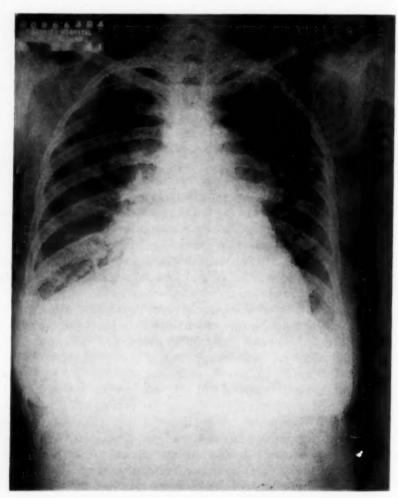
Case 1. Roentgen-ray shows passive congestion of the lung fields. The heart is diffusely enlarged. Large aneurysm is present on the arch of the aorta.
